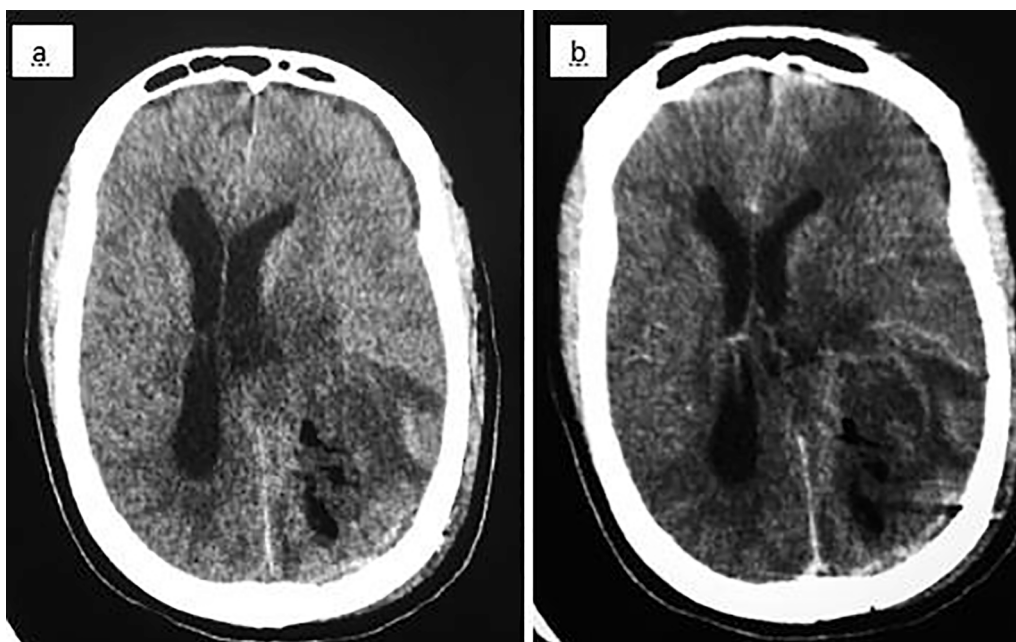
Post-operative cranial CT images; a. pre-contrast image, b. post-contrast image.
